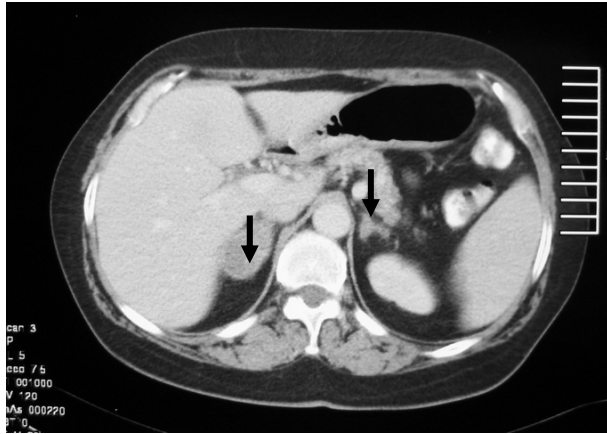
Abdominal CT: two nodules were detected; one originating from the medial crus in the right suprarenal gland measuring 42 x 28 mm, and a second one located in the crus adjoining region of the left suprarenal gland measuring 12 mm
